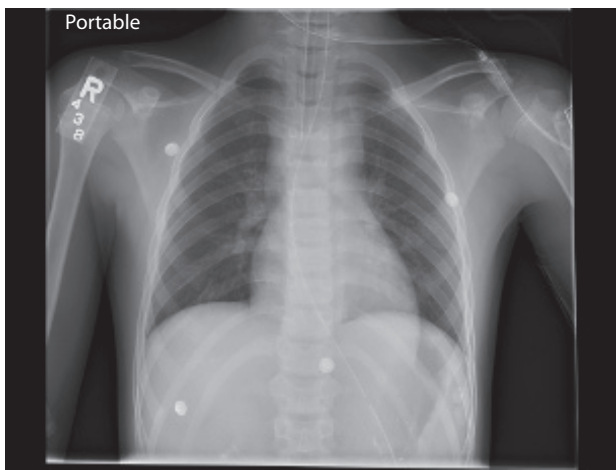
Chest x-ray revealing a widened mediastinum in an 11-year-old patient treated at Texas Children's Hospital after a motor vehicle accident.
